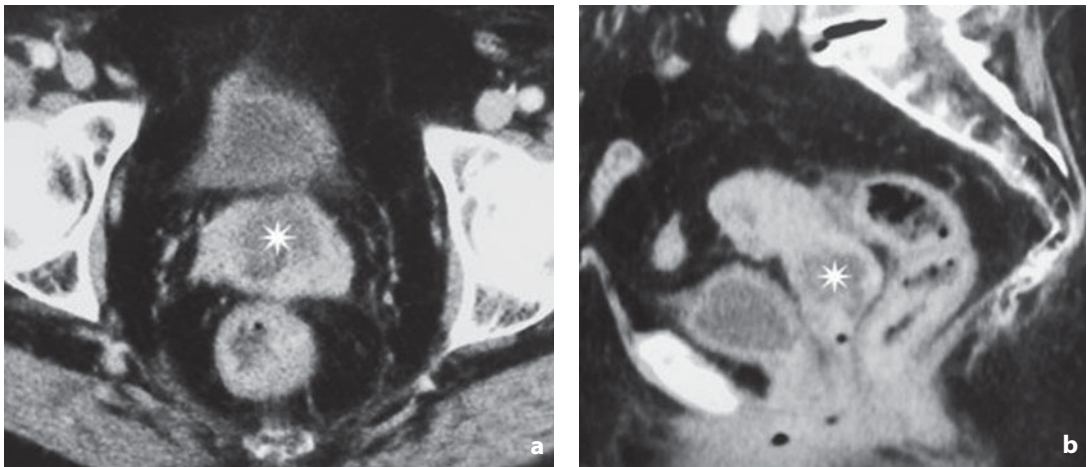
Computed tomography. Cervical cancer in a patient already operated on for colon cancer. Current metrorrhagia. Axial (a) and sagittal (b) images depict carcinoma of the cervix, which appears as a solid hypoattenuating lesion with irregular margins (*asterisk*)
